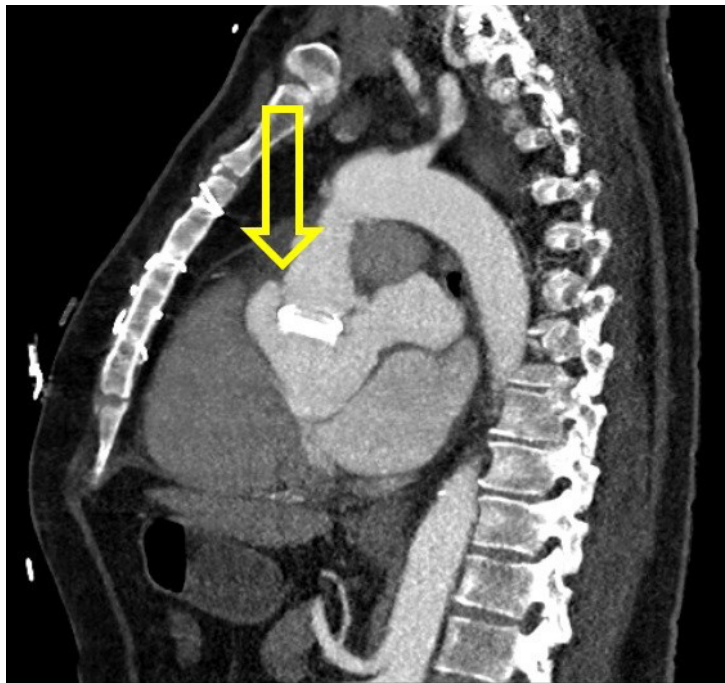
Cardiac computed tomography angiography showed extrinsic compression of the left coronary artery secondary to pseudoaneurysm between the Uni-Graft and mechanical aortic valve.
